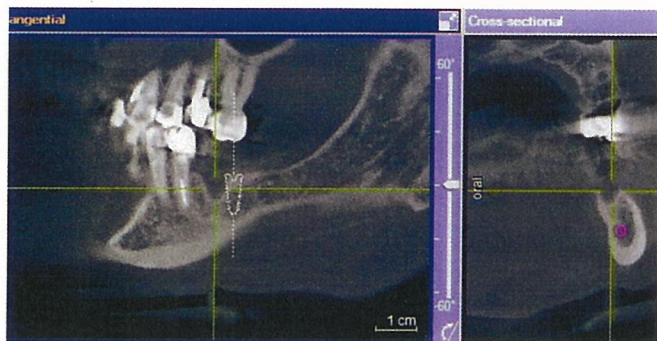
CBCT showing the vertical and horizontal bone loss on site of #19 failed implant
